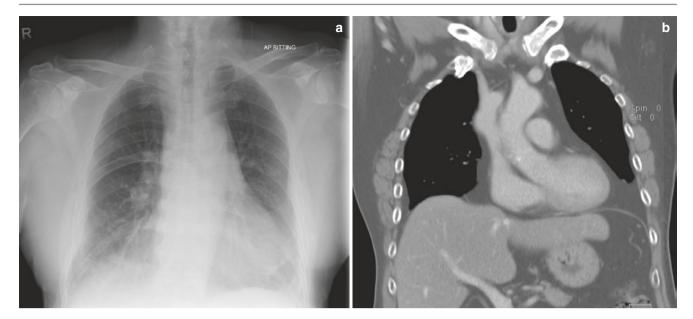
Extrapleural fat mimicking cardiomegaly. (a) Frontal chest radiograph with the appearance of cardiomegaly. (b) Axial CT image shows excessive extrapleural fat mediastinal fat
